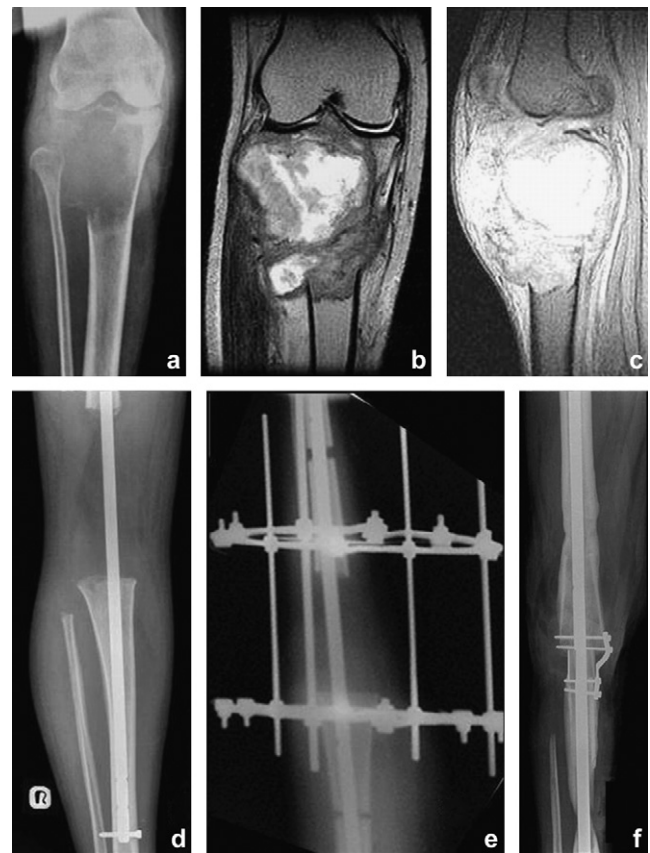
(a) An aggressive GCT of the upper end of tibia infiltrating the soft tissues. (b) and (c) MR images showing the extent of tumor and joint involvement in addition to soft tissue infiltration. (d) Bone gap of 12 cms after wide resection of the tumor and interlocked intramedullary nailing. (e) Bifocal distraction using two-ring Ilizarov construct. (f) End result following plating and bone grafting at the docking site with good union.
